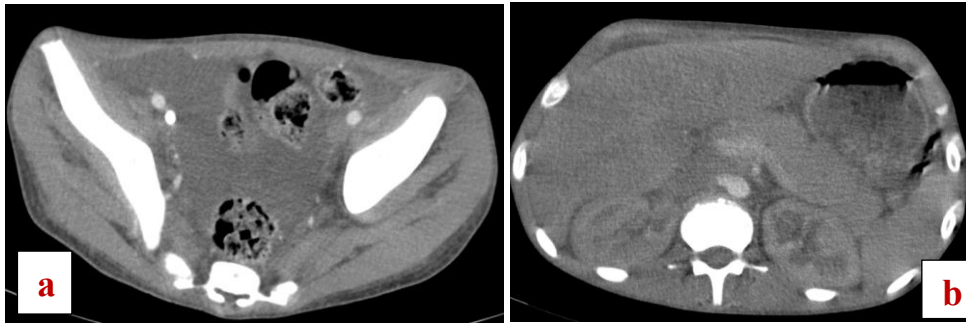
Axial contrast-enhanced abdominal CT showing pancreatic enlargement, with the body measuring 37 mm (a), and a moderate peritoneal effusion (b)
